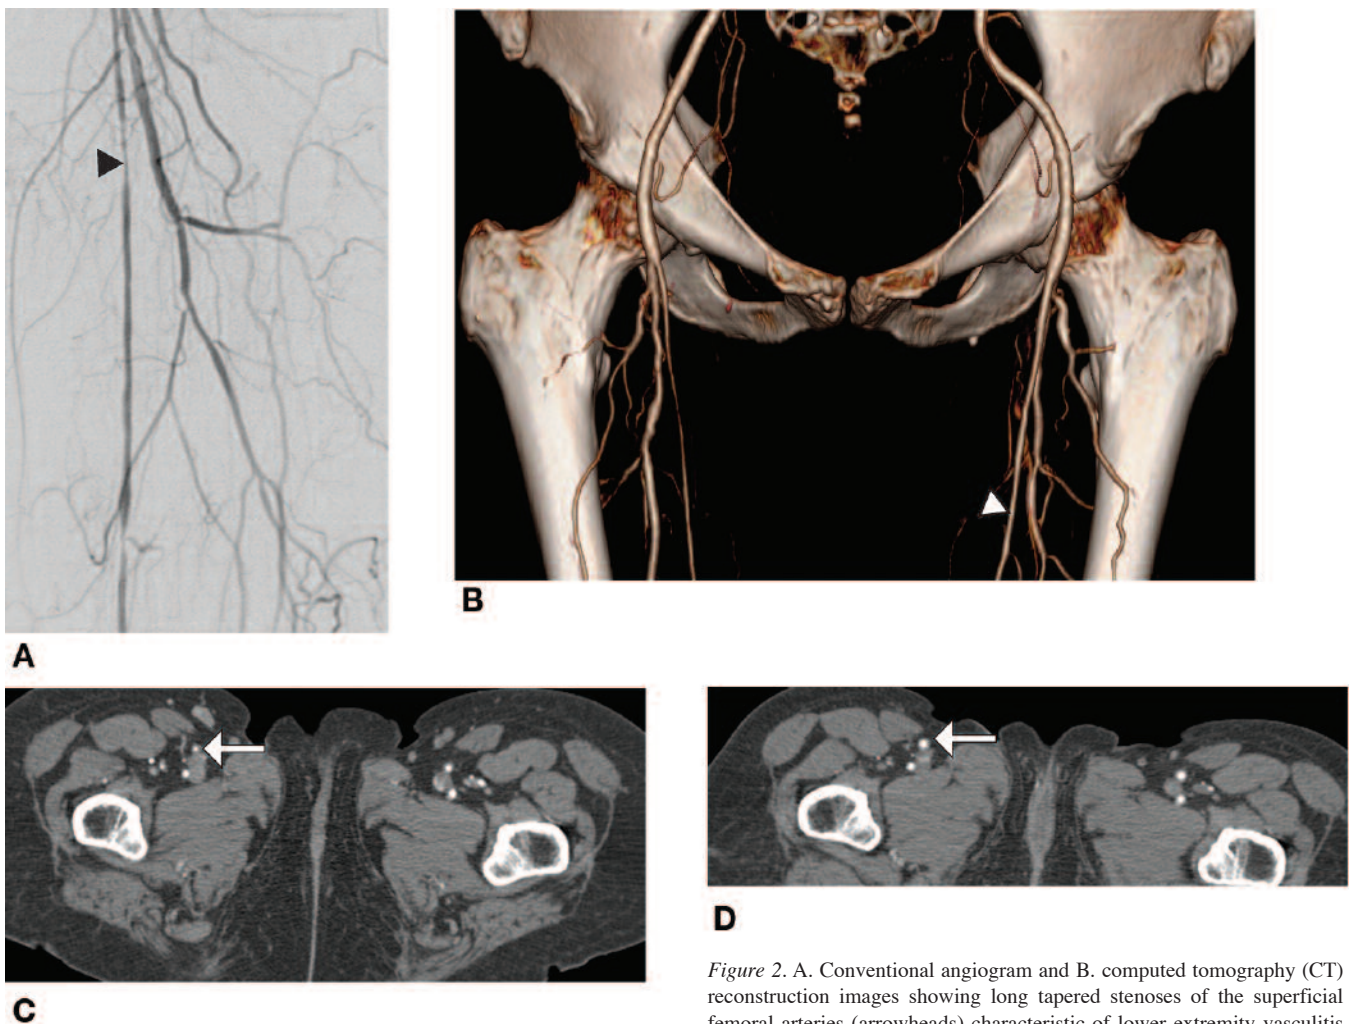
A. Conventional angiogram and B. computed tomography (CT) reconstruction images showing long tapered stenoses of the superficial femoral arteries (arrowheads) characteristic of lower extremity vasculitis from GCA. CT axial images show wall thickening of the superficial femoral artery (arrows) before therapy (C) and after therapy (D).
